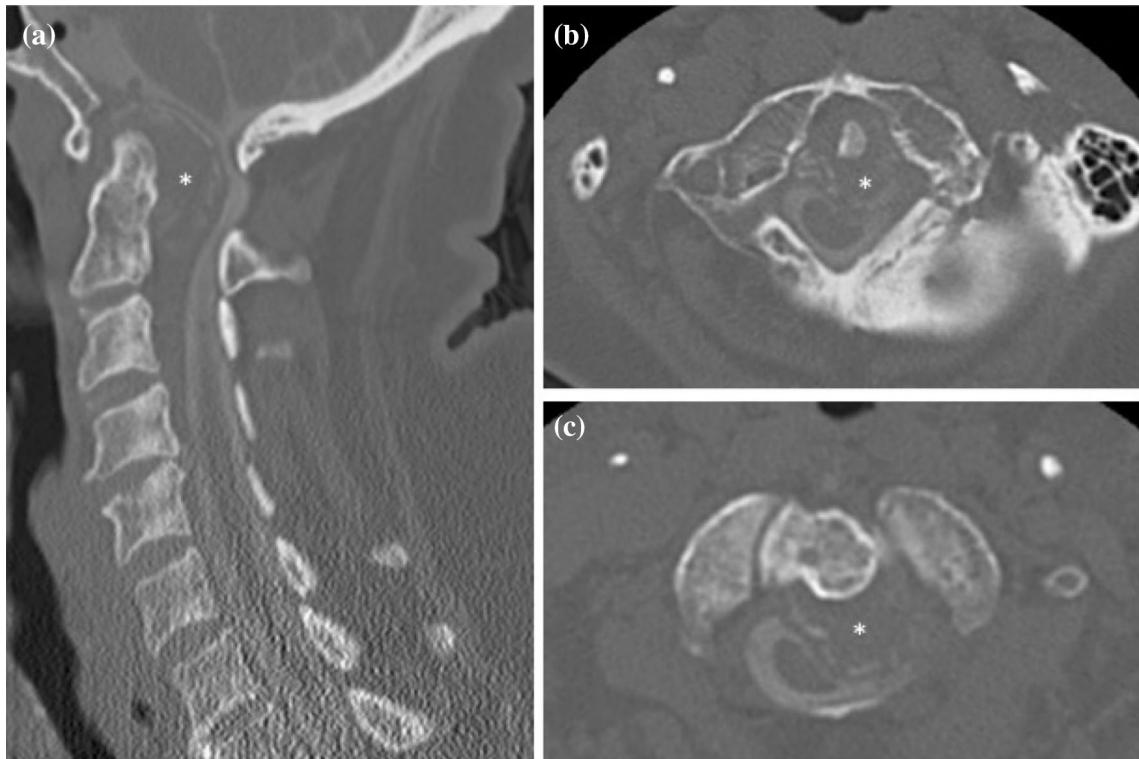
Case 1: Preoperative CT myelography revealed a sizeable retro-odontoid pseudotumor (*). Selective a sagittal and b, c axial images showing the mass effect of the lesion causing significant compression of the spinal cord at the cervical medullary junction
